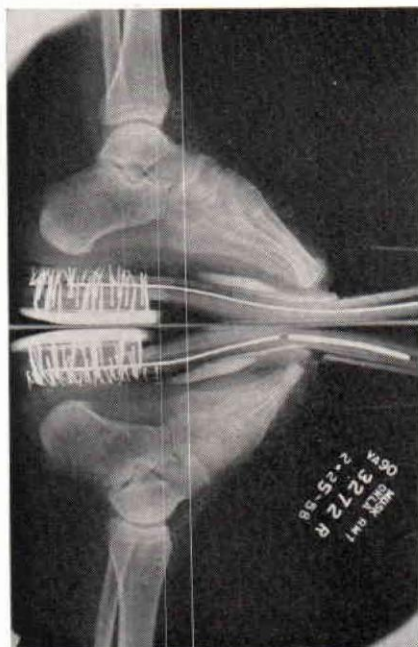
X-ray of Feet in Shoes. Note Broken Heel to Toe Steel on the Right and Absent Toe Block on the Left.
